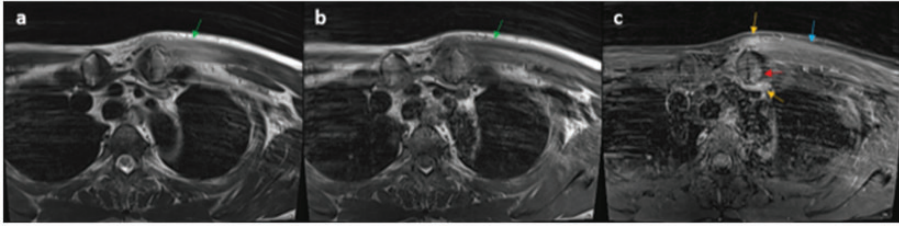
Imaging findings for a 52-year-old man with a 10-day history of left sternoclavicular joint pain (a) Axial T2-weighted and (b) T1-weighted magnetic resonance imaging (MRI) showing fluid accumulation within the left sternoclavicular (SC) joint and edema of the pectoralis major (green arrows) anterior to the left SC joint. (c) Axial fat-suppressed contrast-enhanced T1-weighted MRI showing bone marrow enhancement (red arrow) in the clavicle around the left SC joint and peri-SC joint enhancement (orange arrows). Enhancement of the left pectoralis major muscle (blue arrow) around the left SC joint is also visible.
